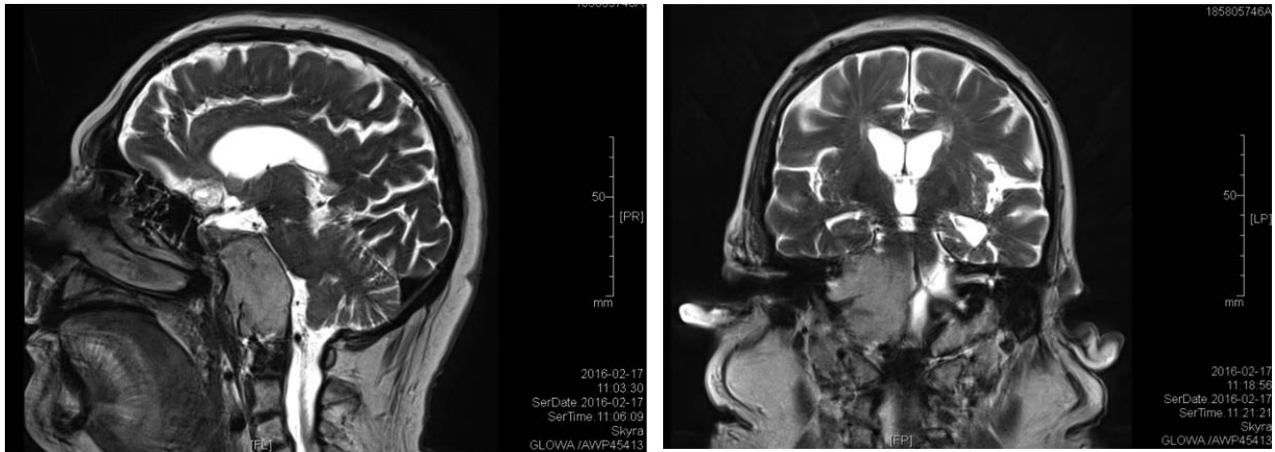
MRI of the pituitary, February 2016
